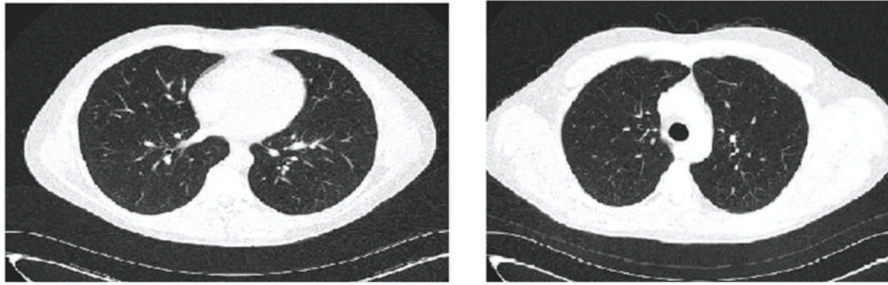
CT scan showed complete resolution of previously observed ground glass opacities with no suspicious nodules or consolidation.
